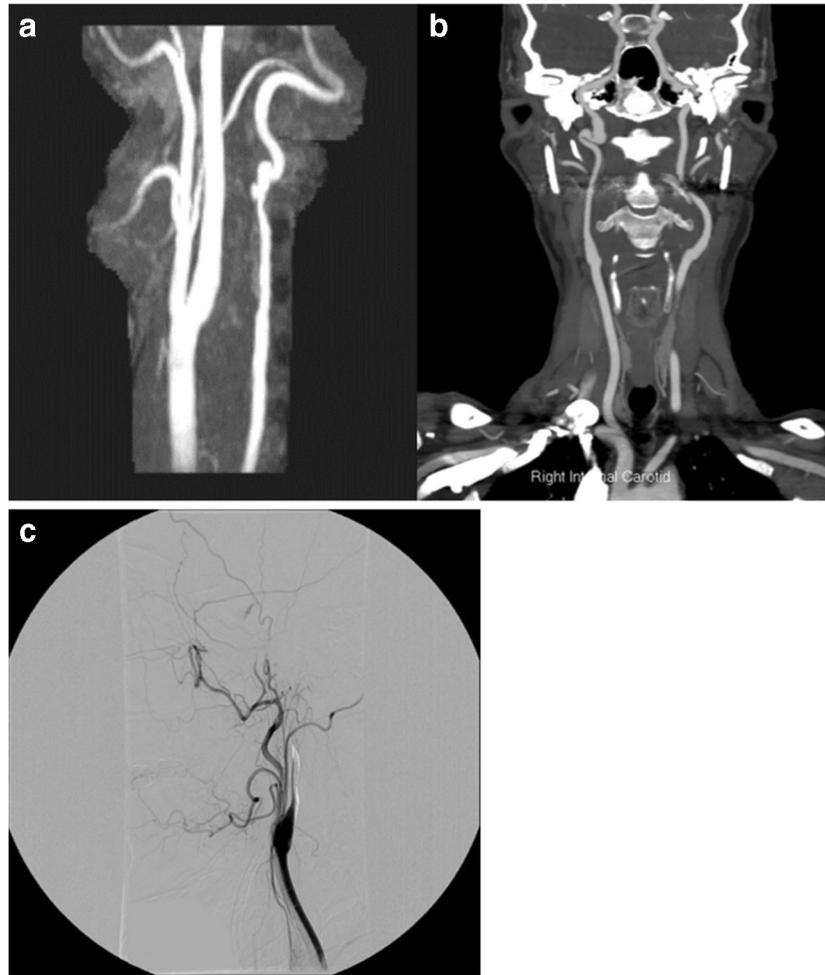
Examples of common CeAD patterns. a Magnetic resonance angiography (MRA) in shows stenosis of the right vertebral with an accompanying pseudoaneurysm. b Coronal view of a computed tomography angiography (CTA) depicting pseudoaneurysm formation in the right internal carotid artery (ICA) just before entering the skull through the foramen lacerum. c Digital subtraction angiography showing tapering of the left ICA before completely occluding distally. Figure 2 is generated from depersonalized images from patients at University Hospitals Cleveland Medical Center.
